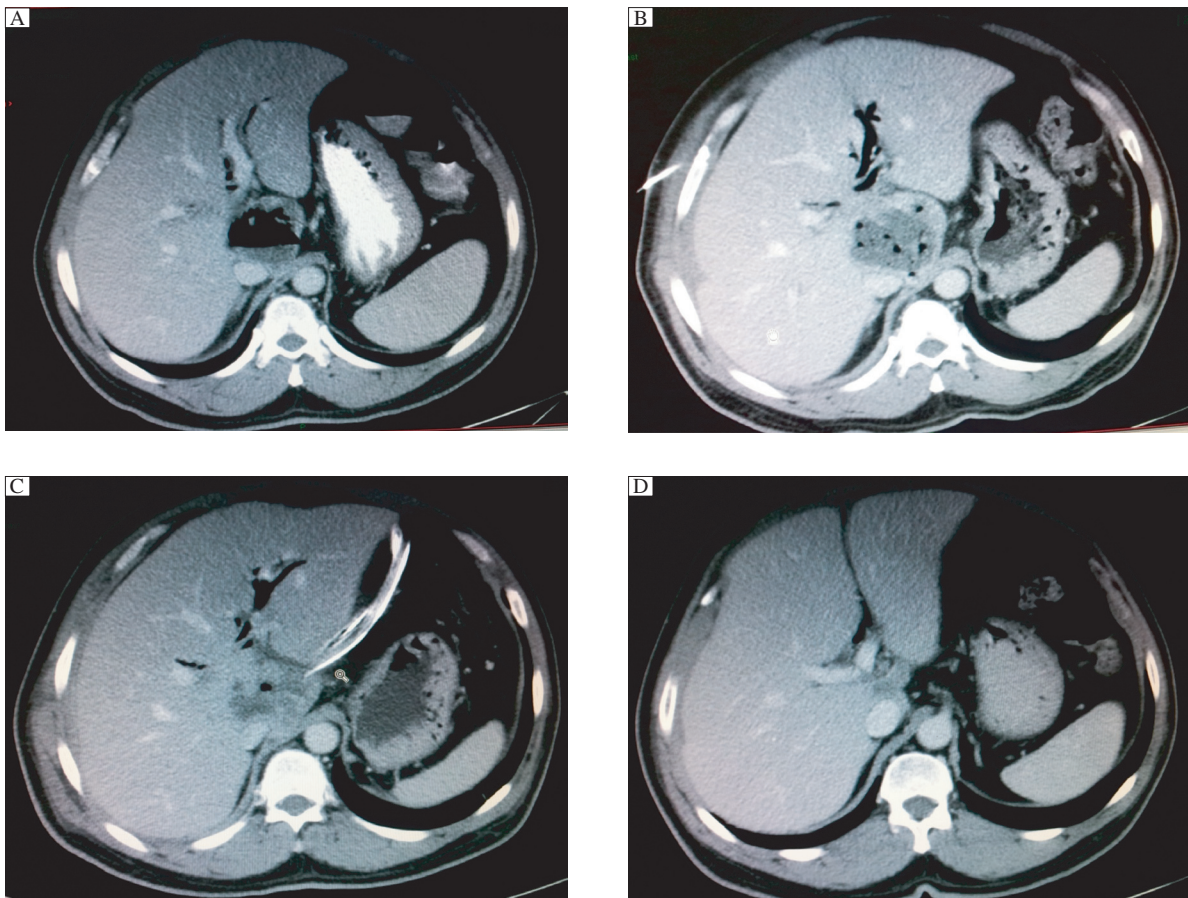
CT results of the patient. A: CT on admission showing caudate lobe abscess; B: CT after percutaneous drainage showing persistence of caudate lobe abscess; C: CT on the fifth post operative day showing obvious regression of the abscess cavity; D: Follow up CT two weeks after surgical drainage showing significant regression of the abscess cavity.
